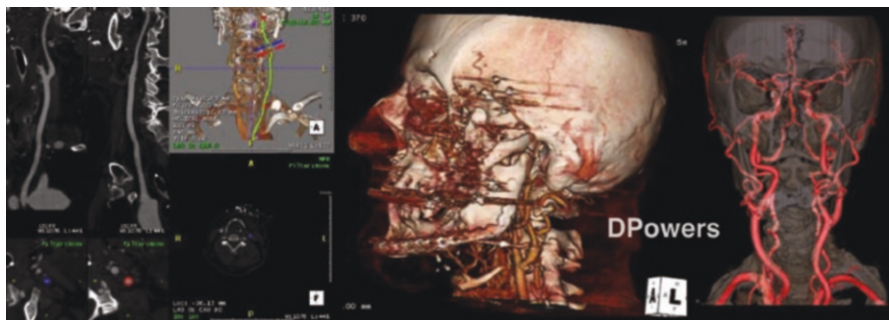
CT angiograms with 3D reconstruction, which can serve as a valuable resource in the identification of potential vascular injury to the vessels of the head and neck
